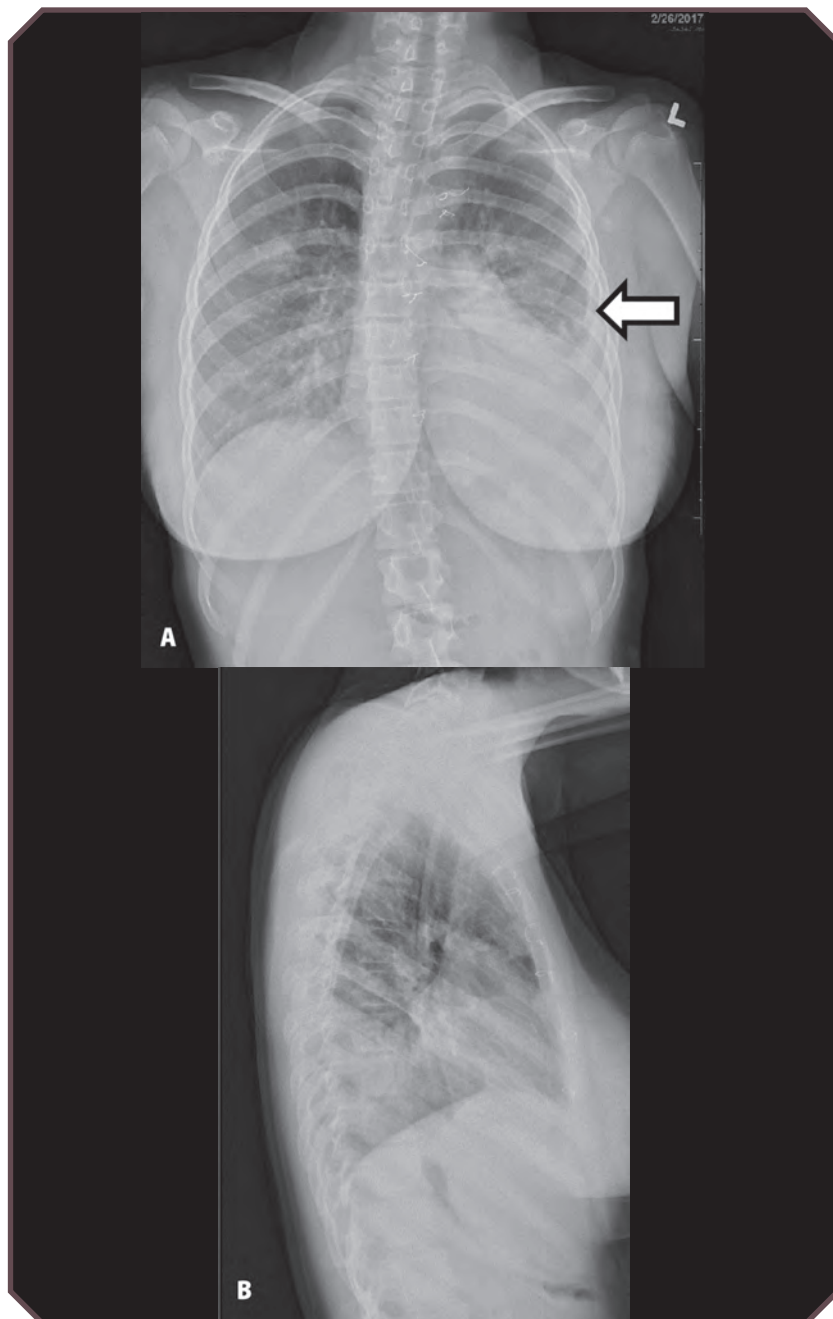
Left lower-lobe pneumonia with effusion. A. Frontal and B. lateral chest radiographs show focal opacity with air bronchograms and obscuration of the left hemidiaphragm. On A, a subtle effusion is seen tracking along the left pleural margin (arrow). Sternotomy wires from old surgical repair of congenital heart anomaly are incidentally noted.
